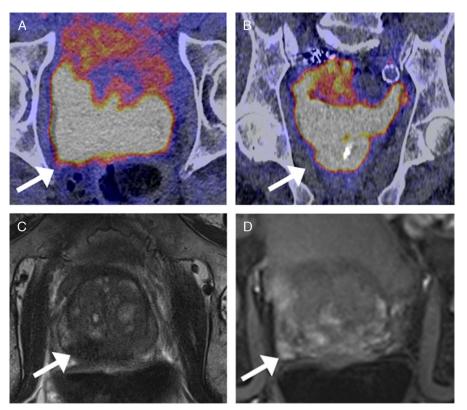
A 73-year-old man with PSA 12 ng/mL and prostate cancer diagnosed by systematic TRUS biopsy (Gleason score 5 + 4 in both sides). On axial and coronal ⁶⁸Ga-PSMA PET/CT (A, B), the prostate was prospectively read as negative for cancer, and the high activity in the pelvis was interpreted as spillover from the bladder (arrows). Multiparametric MRI (performed 3 days later) revealed multiple areas suggestive of prostate cancer, of which the largest lesion is shown on T2-weighted (C, arrow) and contrast-enhanced (D, arrow) images. Furthermore, numerous suspicious lymph nodes and bone lesions were seen (not shown). Spillover from the bladder is a well-known phenomenon in ¹⁸F-FDG-PET,⁷ but also appears to be an issue in ⁶⁸Ga-PSMA PET.⁸ Despite the fact that PET/CT scanning was done after administration of furosemide and bladder emptying in this patient, bladder spillover could not be prevented. Even though it did not have any impact on patient management in this case, bladder spillover can be a source of clinically relevant false-negatives on ⁶⁸Ga-PSMA PET/CT in other patients. Particular caution and additional mpMRI should be warranted in patients with considerable bladder spillover and who do not have any signs of extraprostatic disease on ⁶⁸Ga-PSMA PET/CT.
